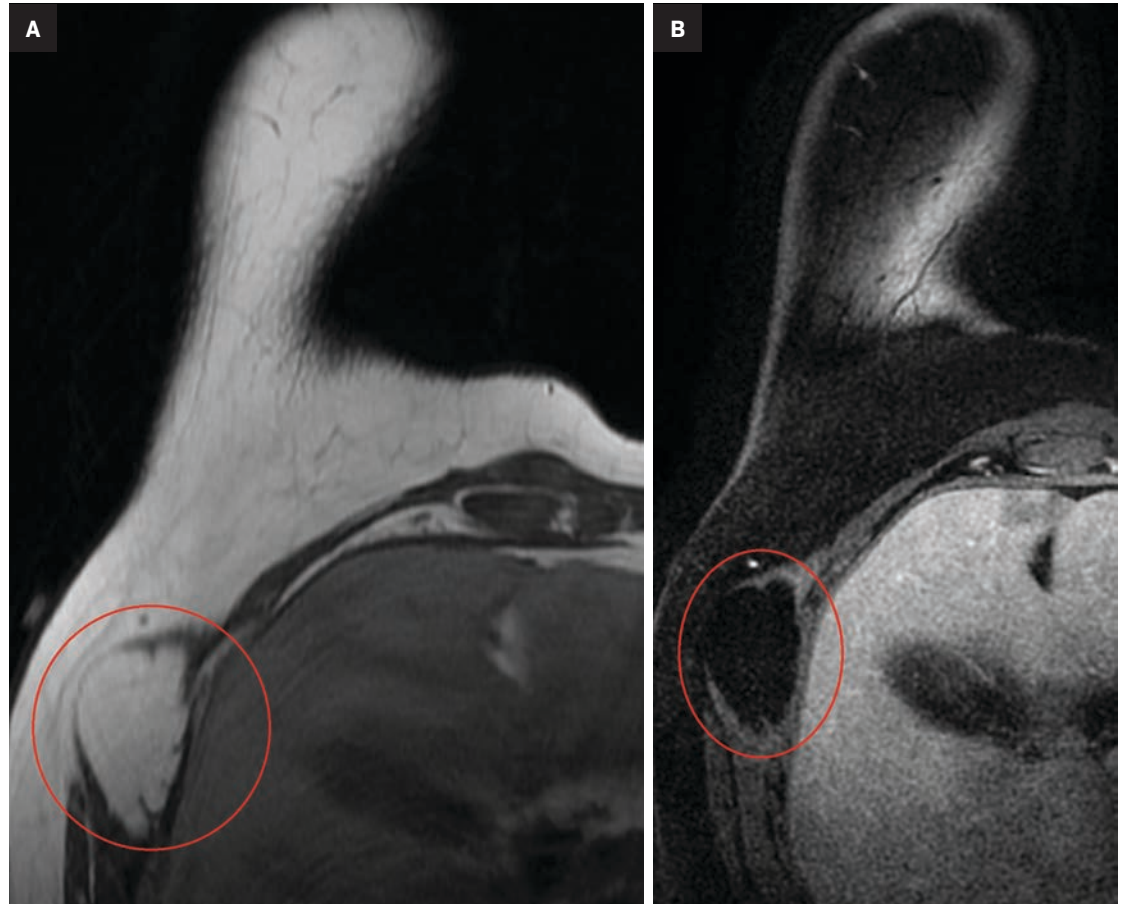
(A) Axial T1 and (B) T1 fat-suppressed postcontrast MR images of the right breast. There is a nonenhancing, T1 hyperintense mass in the lateral chest wall musculature that has signal loss on fat-suppressed sequence consistent with an intramuscular lipoma (circles).
